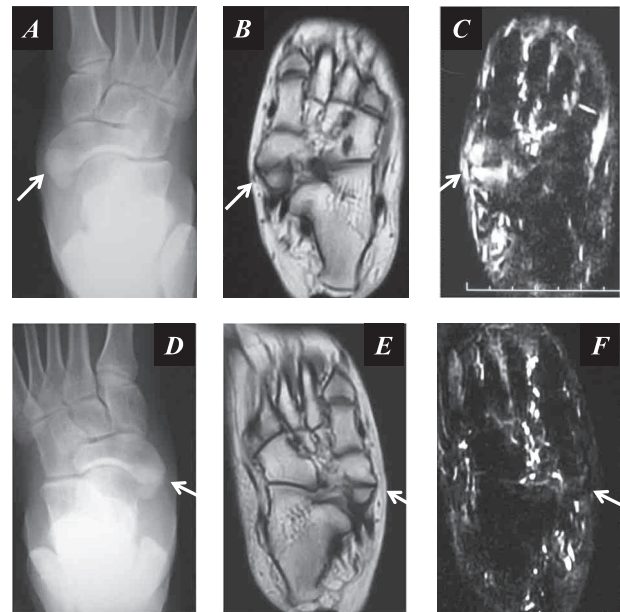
Bilateral type II accessory navicular bones in case 1. Anteroposterior radiograph (A) of the symptomatic (right) side shows a type II accessory navicular bone (arrow). The ipsilateral T1-weighted (B) and T2-weighted fat saturated (C) horizontal MR images demonstrate edema-like bone marrow pattern on the both the accessory navicular bone and the navicular tuberosity facing to the synchondrosis (arrows), which might be described as “kissing edema pattern”. In contrast, despite the presence of accessory navicular bone (D), asymptomatic navicular bone (in the left foot) does not show edema-like bone marrow pattern on either T1-weighted (E) or T2-weighted fat saturated (F) MR image (arrows).
